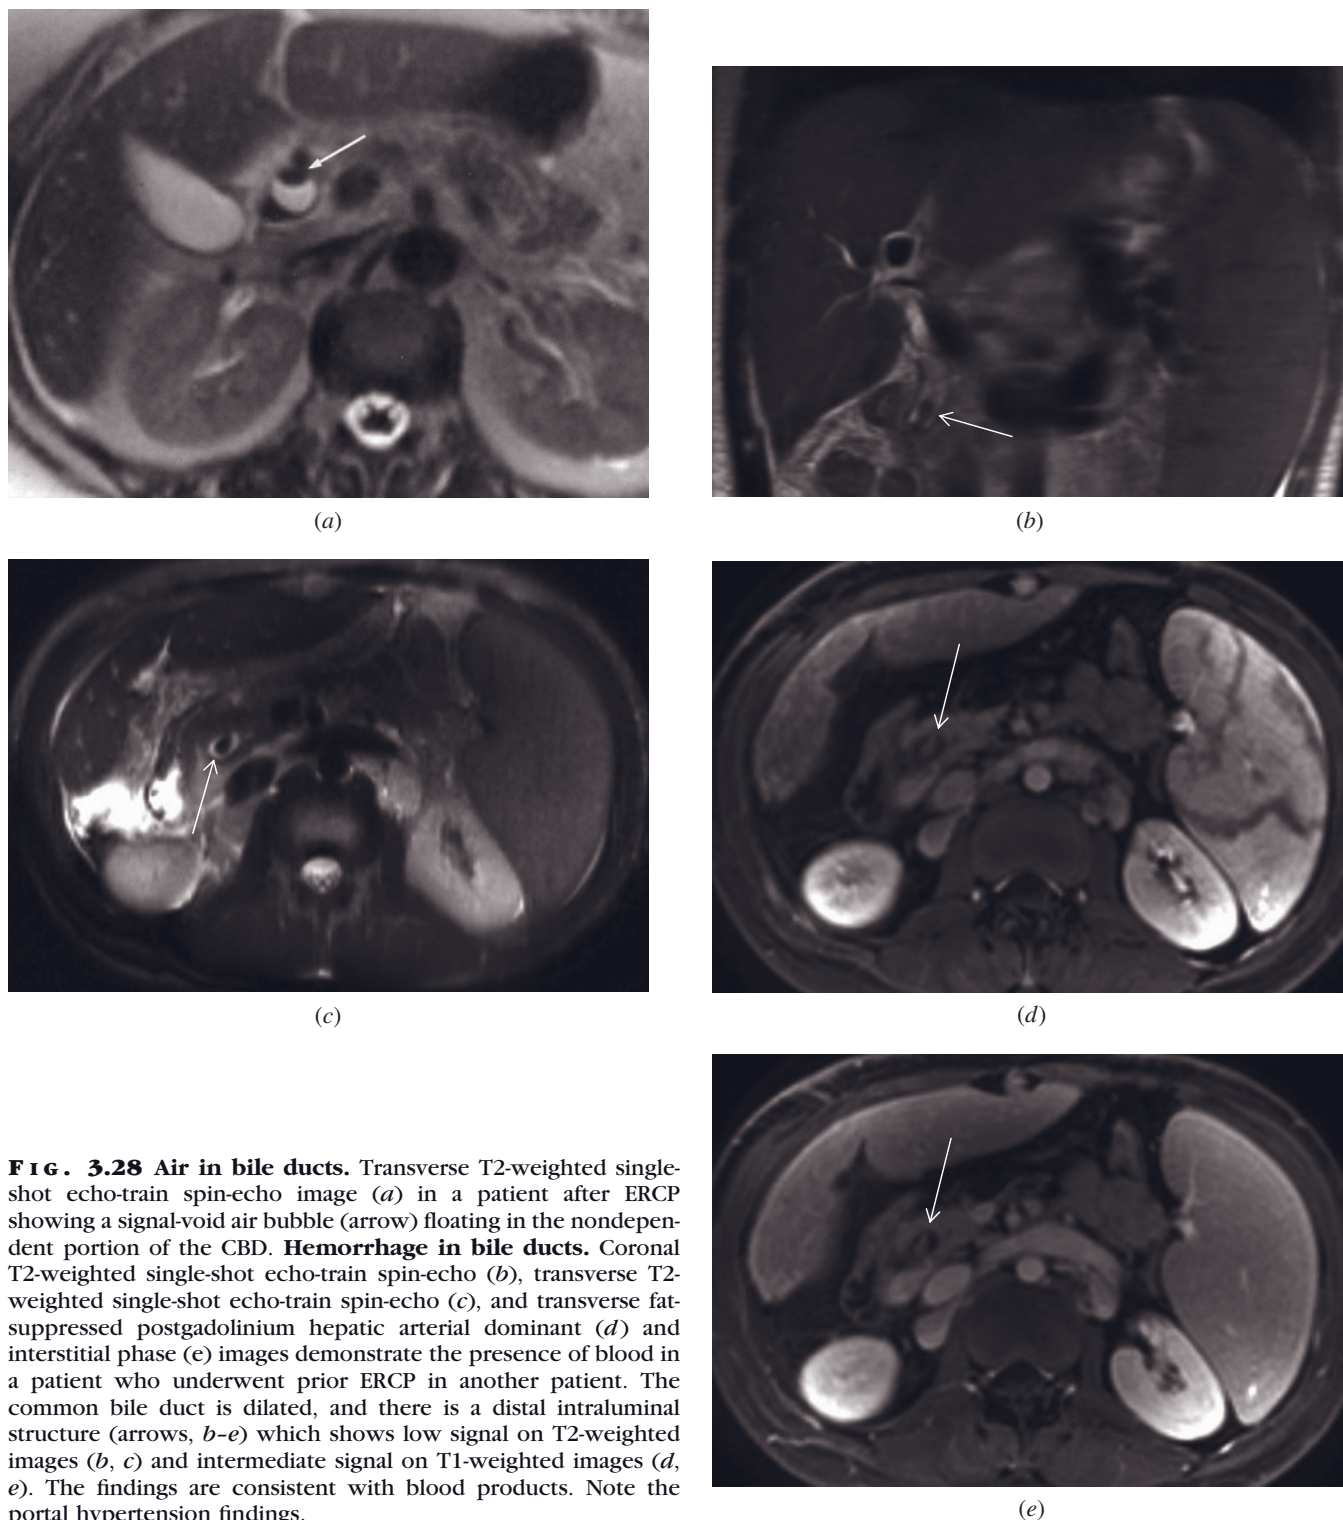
Air in bile ducts. Transverse T2-weighted single-shot echo-train spin-echo image (a) in a patient after ERCP showing a signal-void air bubble (arrow) floating in the nondependent portion of the CBD. Hemorrhage in bile ducts. Coronal T2-weighted single-shot echo-train spin-echo (b), transverse T2-weighted single-shot echo-train spin-echo (c), and transverse fat-suppressed postgadolinium hepatic arterial dominant (d) and interstitial phase (e) images demonstrate the presence of blood in a patient who underwent prior ERCP in another patient. The common bile duct is dilated, and there is a distal intraluminal structure (arrows, b-e) which shows low signal on T2-weighted images (b, c) and intermediate signal on T1-weighted images (d, e). The findings are consistent with blood products. Note the portal hypertension findings.
